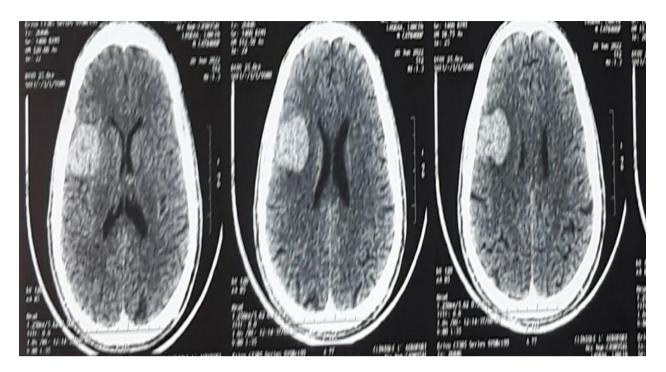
Cerebral CT scan showing the lesional parietal process metastasis discreetly compressive
